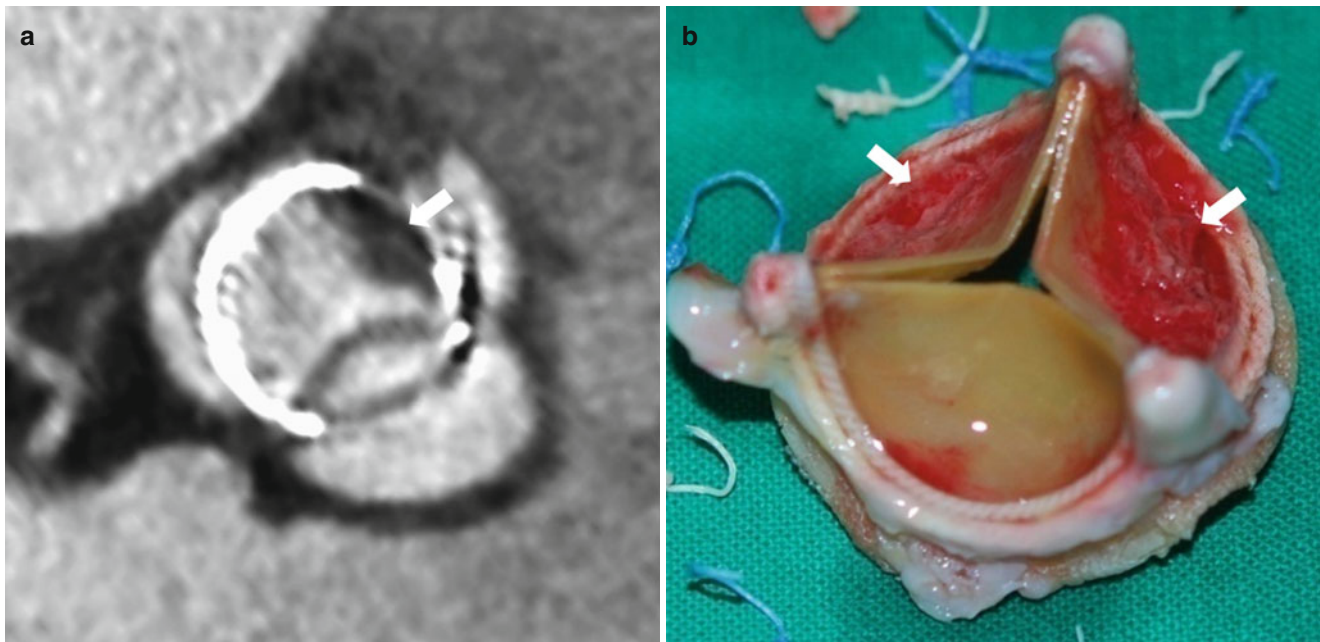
Thrombus formation involving the prosthetic aortic valve. (a, b) Oblique axial CT image (a) obtained during mid-systole shows low-density thrombus formation involving leaflet of biological
